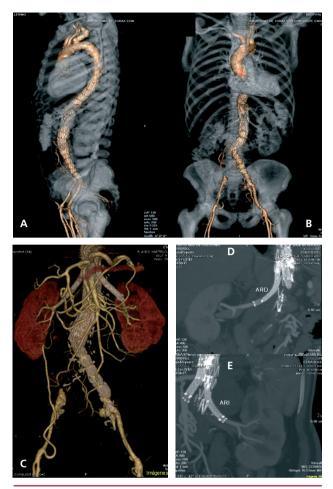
Computed tomography scan performed in the immediate postoperative period (A and B) and after 6 months (C, D and E).
